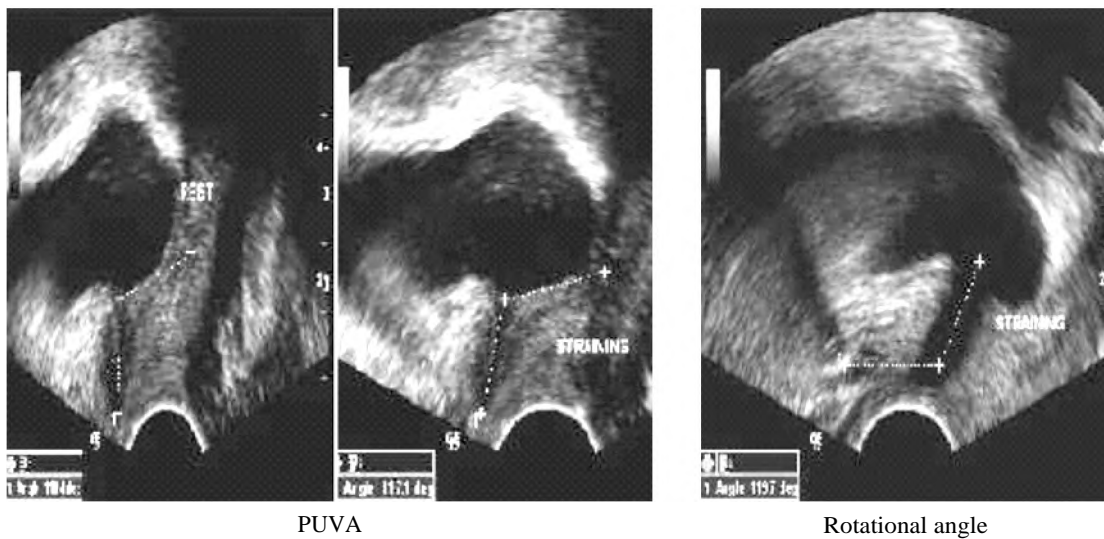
Transperineal ultrasound of a female patient complaining of mixed urinary incontinence shows widening of the posterior urethral angle. (PUVA is an angle formed between a line drawn tangent the proximal half of the urethra and a line tangent the infero-posterior aspect of the bladder base). And also shows increased in the rotational angle (which refers to the slope of the proximal half of the urethral axis with respect to the x axis of the pubic bone).
